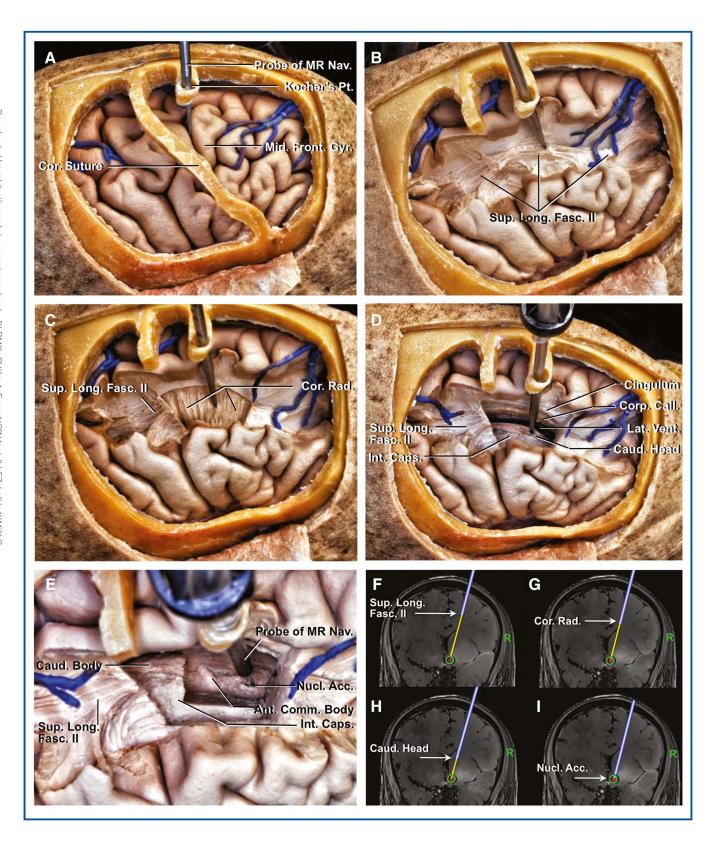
Nucleus accumbens (NAc) exposure with MR navigation. A, a right frontoparietal craniotomy with preservation of the coronal suture has been performed to show the structures encountered in passing a probe from Kocher's point, 2 cm lateral to the midline and 2 cm anterior to the coronal suture, to the NAc, as used for deep brain stimulation. Opening the dura exposes the middle frontal gyrus. B, the first tract exposed deep to the U-fibers is the SLF II, underlying the middle frontal gyrus. C, the anterior part of the SLF II has been reflected posteriorly to expose the corona radiata. D, removing the corona radiata exposes the head of the caudate nucleus. The lateral ventricle has been exposed medial to the head of the caudate nucleus. The dissection also exposes the corpus callosum and cingulum. E, the NAc is encountered inferior to the head of the caudate nucleus and anterior to the body of the anterior commissure. F-I, coronal MR imaging showing the MR navigation in T1-weighted images. The arrows in F-I at the junction of the blue and yellow trajectories show the level at which the superior longitudinal fasciculus II, corona radiata, caudate head, and NAc are encountered in B-E. The NAc is located at the green circle. Acc., accumbens; Ant., anterior; Caps., capsule; Caud., caudate; Comm., commissure; Cor., corona; Corp. Call., corpus callosum; Fasc., fasciculus; Front., frontal; Gyr., gyrus; Int., internal; Lat., lateral; Long., longitudinal; Mid., middle; MR, magnetic resonance; Nav., navigation; Nucl., nucleus; Pt., point; Rad., radiata; Sup., superior; Vent., ventricle.
